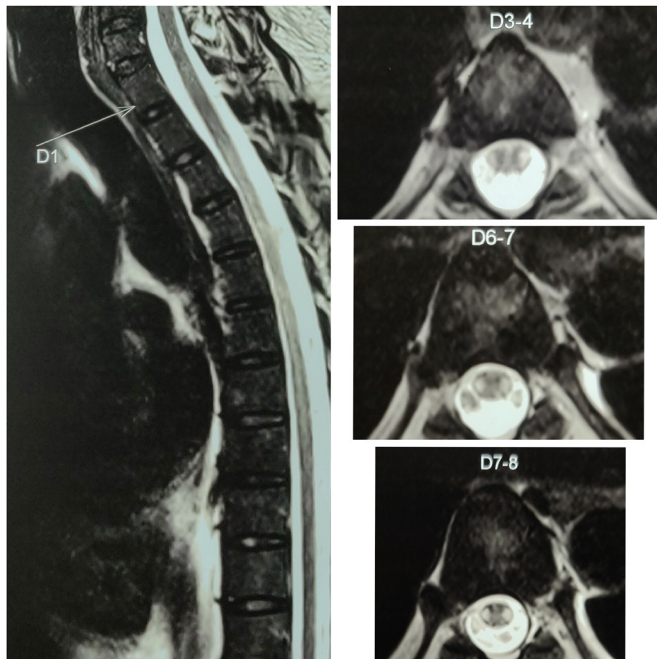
MRI spinal cord at presentation: (sagittal) T2 signal changes extending longitudinally from D3 to D9 and dorsal cord (axial) T2 sequence showing intensity changes predominantly in the bilateral lateral column.
